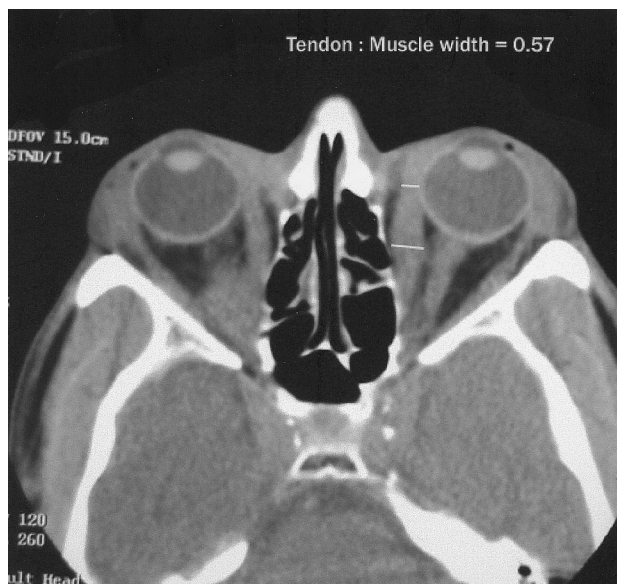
Moderate involvement of muscle tendon on computed tomography scan of a patient with thyroid-associated orbitopathy (fusiform enlargement, tendon/muscle ratio 0.57).
